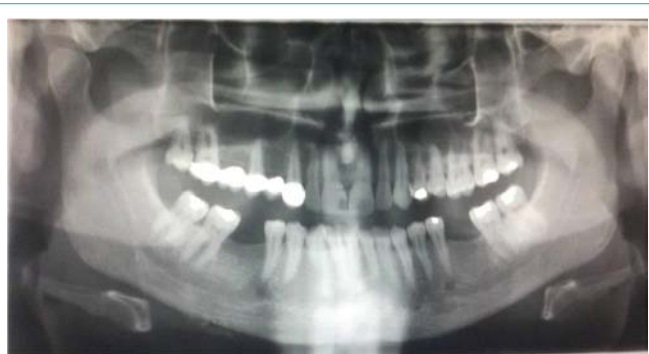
Post-operative Panoramic radiograph after removal of the stones.
